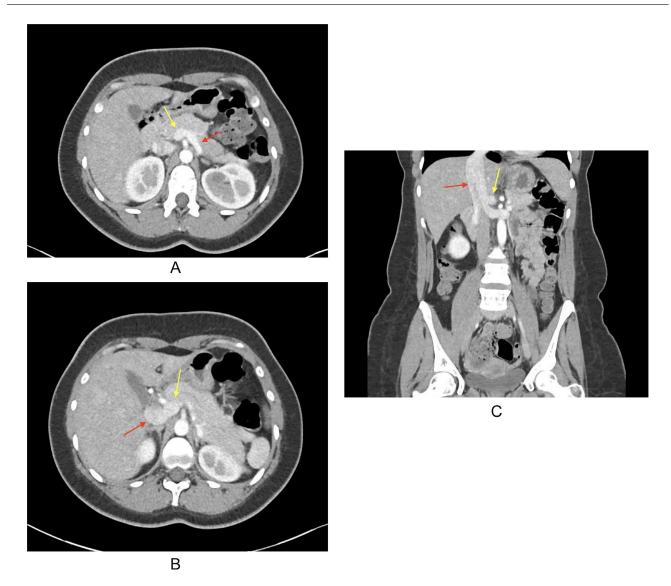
(A) Axial contrast-enhanced CT through the abdomen showing the superior mesenteric vein (yellow arrow) joining the splenic vein (red arrow) to create a common trunk. (B) Axial contrast-enhanced CT through the abdomen showing the common trunk (yellow arrow) formed from the confluence of the superior mesenteric vein and splenic veins joining into the inferior vena cava (red arrow). (C) Coronal contrast-enhanced CT through the abdomen showing the common trunk (yellow arrow) formed from the confluence of the superior mesenteric vein and splenic veins joining into the inferior vena cava (red arrow).
